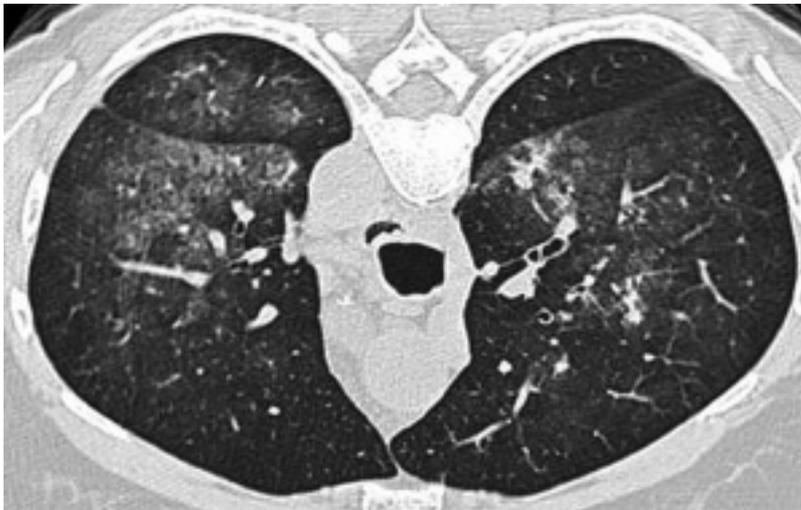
Computed tomography scan of the thorax shows diffuse ground-glass opacification of both lungs. The distribution is perihilar.
